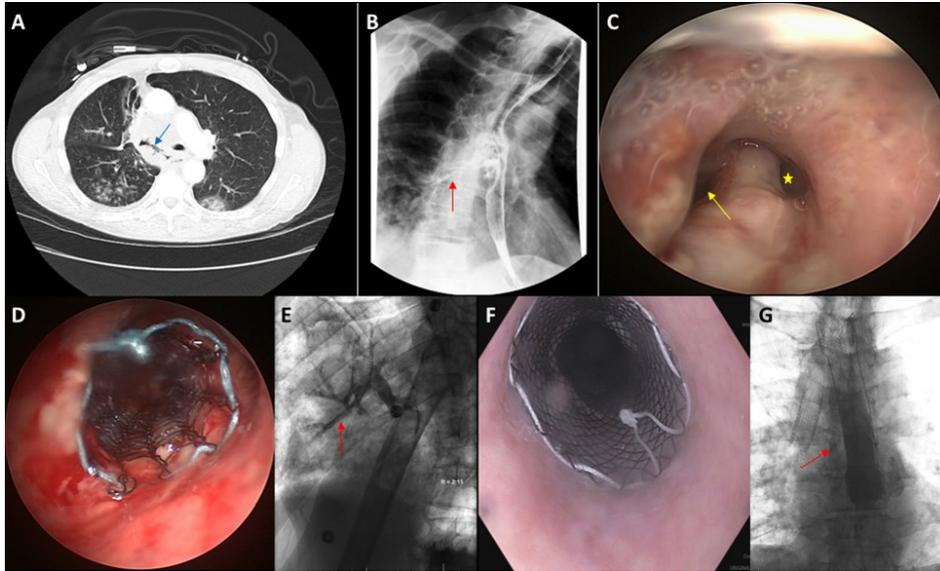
Post-radiation broncho-esophageal fistula seen on a CT scan (Panel A, blue arrow), with adjacent right lower lobe opacities consistent with aspiration. Esophagram demonstrated aspiration of contrast into the airways forming a contrast bronchogram (Panel B, red arrow). A large fistula in the proximal bronchus intermedius was visualized during bronchoscopy (Panel C, yellow arrow). Airway leading to the right middle and lower lobe is also seen (Panel C, yellow star). The fistula was covered with a 14 mm X 40 mm partially covered Ultraflex SEMS (Panel D). However, there was residual leak of contrast into the airway on a follow-up esophagram (Panel E, red arrow), which warranted placement of an esophageal SEMS (Panel F). Minimal leak of contrast was noted after double stenting (Panel G, red arrow).
